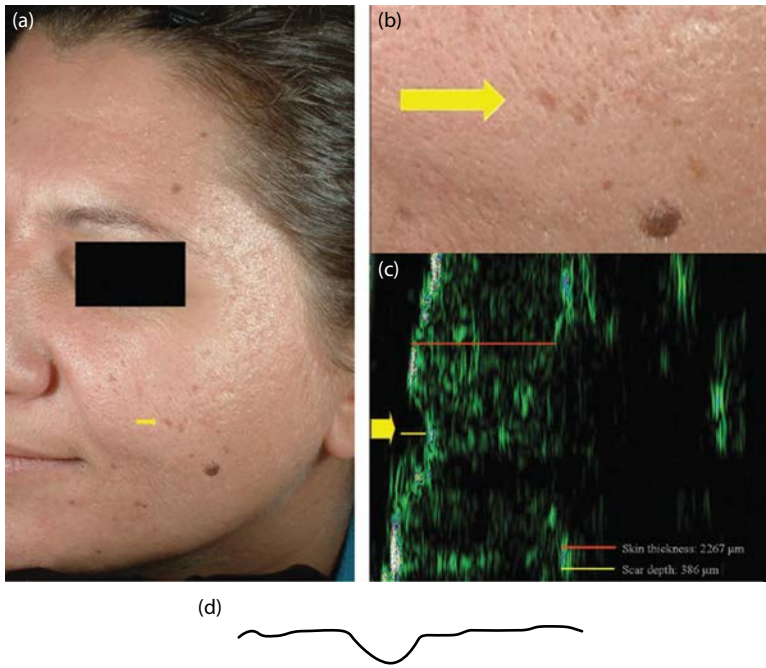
Boxcar scar: (a,b) clinical and (c) ultrasound appearance; (d) cross-sectional profile.
